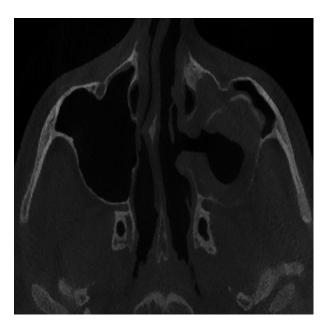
Axial computed tomography image obtained at 1 month after surgery. The patient was treated with functional endoscopic sinus surgery (FESS) combined with an intraoral approach. The radiolucency in the cystic compartment testifies the presence of inflated air.
